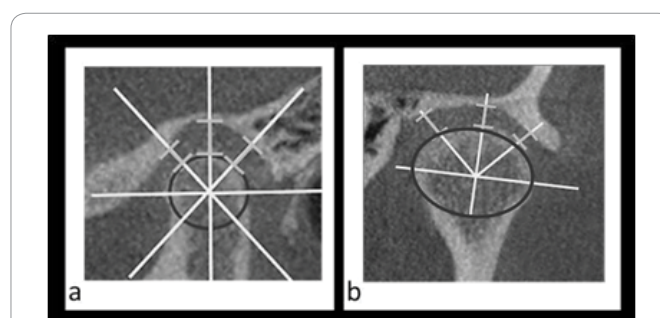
Measurement model in TMJ CBCT: sagittal (a) and coronal (b) cuts.
